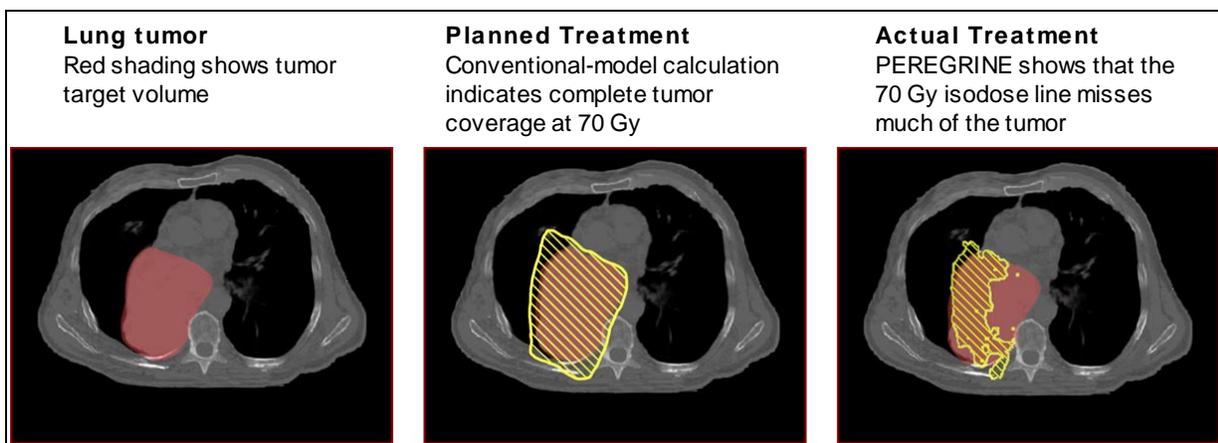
Comparison of PEREGRINE calculations with a conventional dose calculation method for a lung cancer patient. This figure shows the position of the prescription isodose level (70 Gy) overlaid on an axial CT-scan slice through the patient's chest. The shaded area in the center of the scan shows the tumor volume, while the contour enclosing hash marks shows the 70 Gy isodose line.
